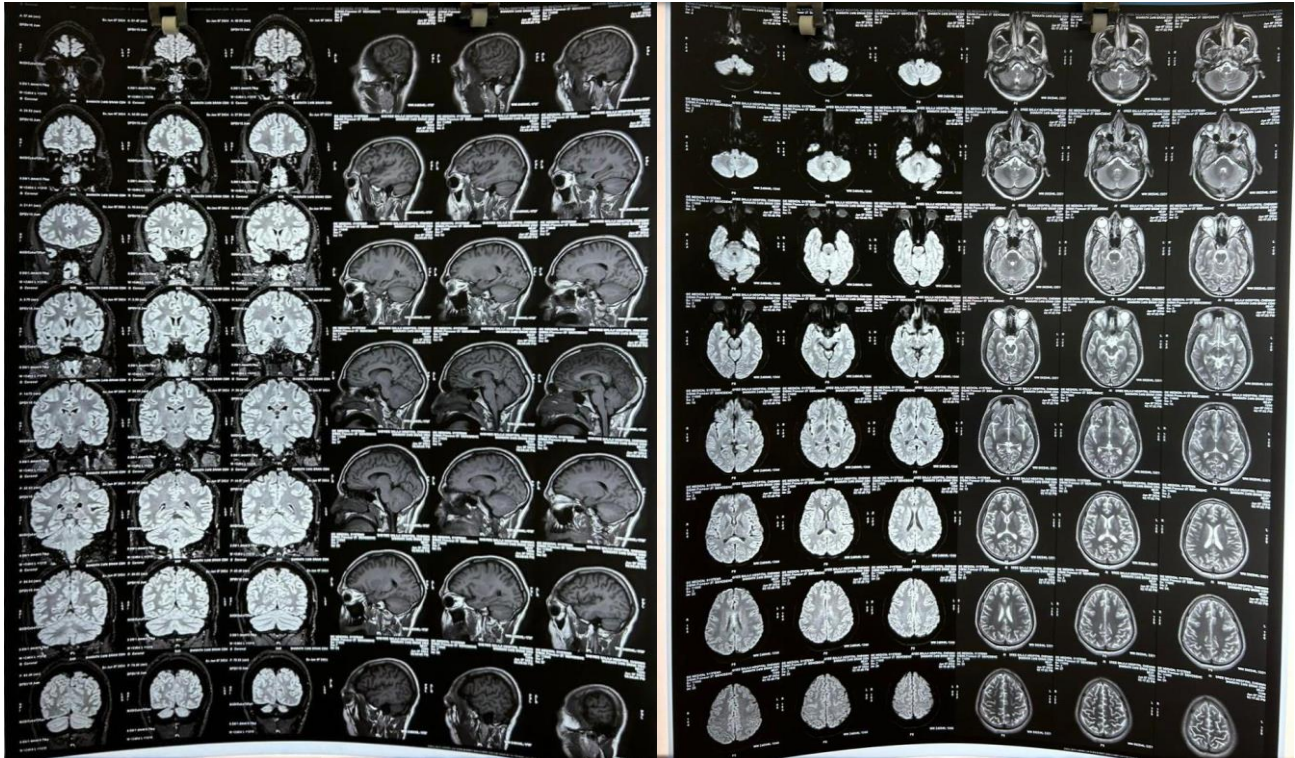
and Fig. 3: MRI Brain showing an area of diffusion restriction in the corpus callosum's splenium, extending into the region of the body, with subtle T2/FLAIR hyperintensity and edema.
